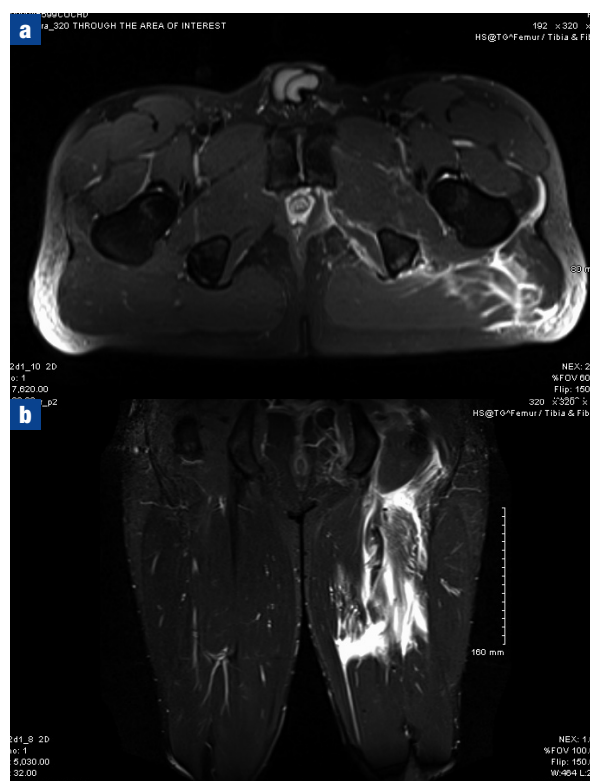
a. Coronal and (b) axial magnetic resonance images of a patient with proximal hamstring tendinopathy showing interface failure of the left semimembranosus and joint tendons with detachment of the tendon origins from the left ischial tuberosity.
